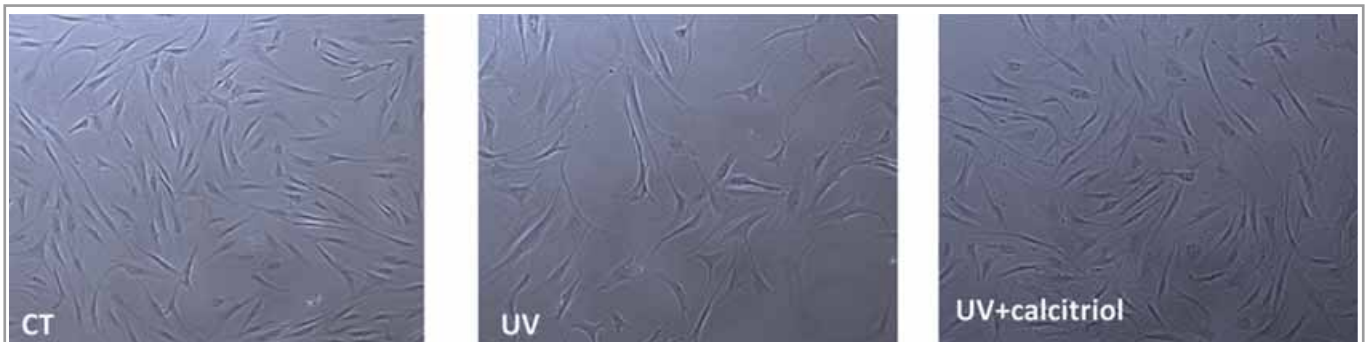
Pictures taken at the end of the recovery period of UVB-induced-SIPS. Cell morphology and number of control (CT) and cells submitted to UVB exposure pretreated with calcitriol are similar, while in the UVB exposed cells condition, cell number is decreased. Arrows indicates senescent cells, flattened and enlarged
